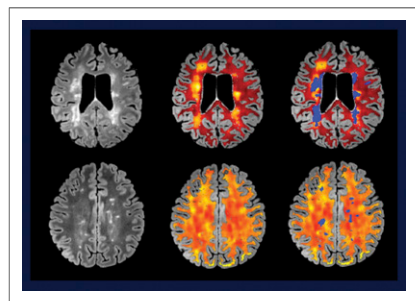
Overlap between white matter MS lesions and ^{18}F -PBR111 uptake on PET. Top row: High overlap seen in (left to right) T2-FLAIR MR, ^{18}F -PBR111 V_T PET, and PET/MR overlay in patient with aggressive MS course. Bottom row: Low overlap seen in corresponding images in patient with benign MS course.
